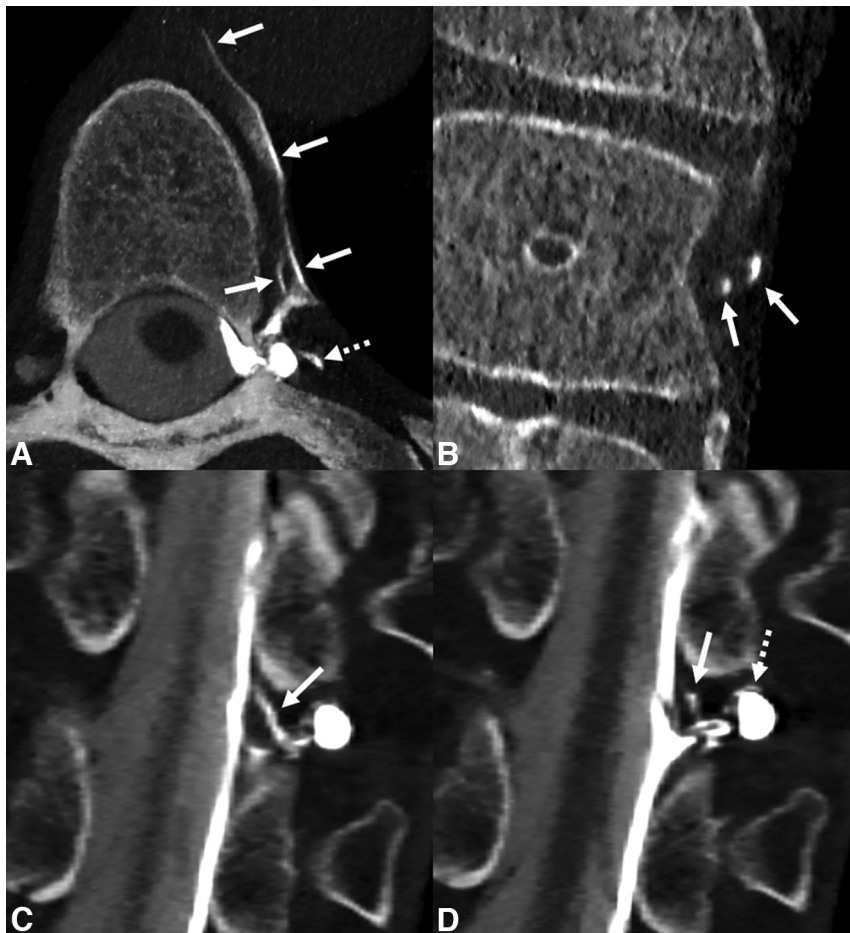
Typical appearance of CVFs on single-day bilateral decubitus CTM in 2 different patients (*A and B* versus *C and D*). In both patients, right lateral decubitus CTM was performed initially with injection of 5 mL Omnipaque 300 (not shown). Subsequently, the spinal needle was removed, the patients were rotated to the left decubitus position, and myelography was repeated with another 5 mL Omnipaque 300 after placement of a new spinal needle. In the first patient, axial (*A*) and coronal (*B*) images demonstrate a left T7 CVF involving the paraspinal segmental vein (*A and B*, solid arrows) and a lateral venous branch (*A*, dashed arrow). In the second patient, whose myelogram was performed on photon-counting CT, coronal 0.2 mm images (*C and D*) demonstrate a left T10 CVF involving the internal epidural venous plexus (*C and D*, solid arrows) and the intervertebral vein (*D*, dashed arrow). Detection of venous opacification immediately adjacent to meningeal diverticula often requires high spatial resolution.
